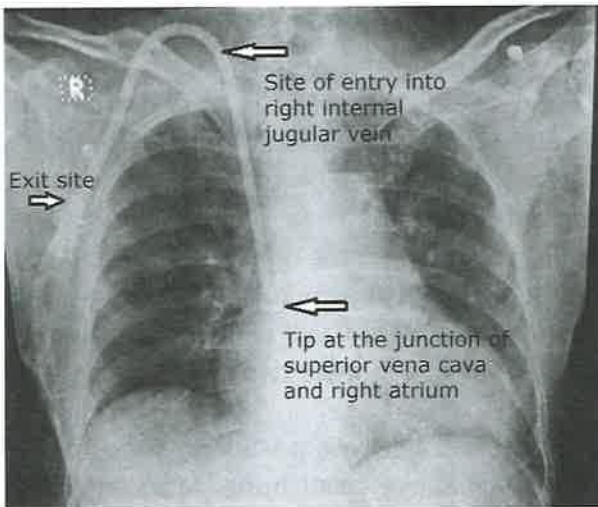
X-ray showing Permcath in right internal jugular vein.
